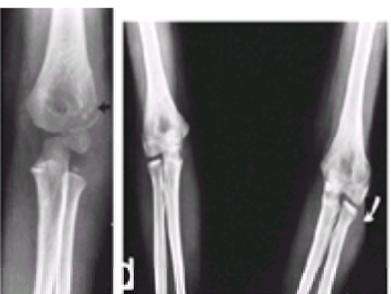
Spur formation. A: Follow-up radiograph of a boy whose lateral condyle was treated nonoperatively. The periosteal flap produced a spur on the lateral aspect of the metaphysis (arrow). This fracture healed with a mild varus angulation as well. B: Clinically, the spur accentuated the lateral prominence (arrow) of the elbow, which in turn accentuated the mild valgus angulation. (Reprinted from Wilkins KE. Residuals of elbow fractures. *Orthop Clin North Am* 1990;21:289-312; with permission.) C: Considerable soft tissue dissection was performed in the process of open reduction of this lateral condylar fracture. D: At 2 months postsurgery, there is a large irregular spur formation secondary to periosteal new bone formation from the extensive dissection.
